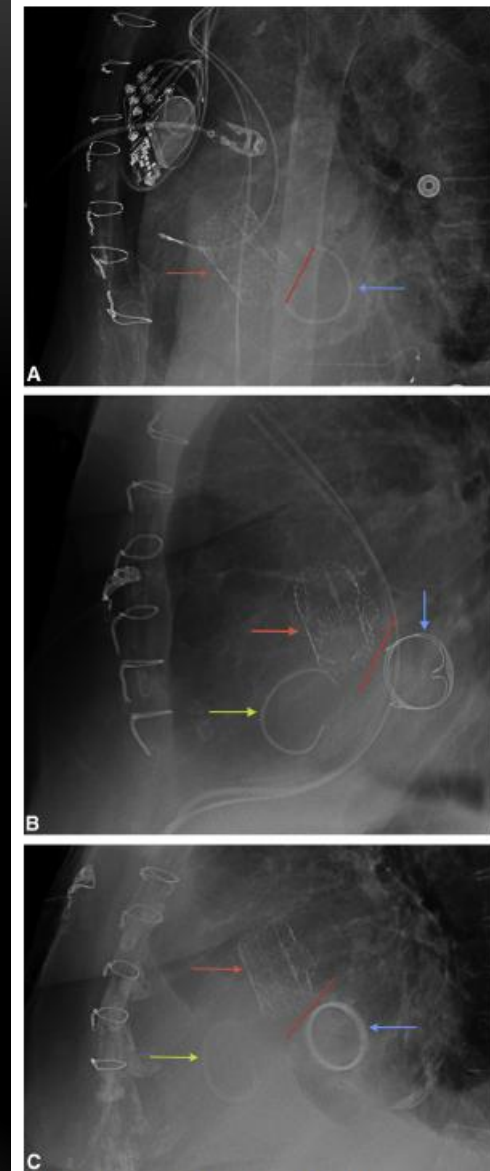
Postoperative lateral chest radiographs showing the absence of interference between the Perceval S and mitral prostheses. A, Sorin Annuloflex partial ring for mitral annuloplasty. B, Carpentier-Edwards Perimount Magna Mitral Ease bioprosthetic valve. C, Sorin Carbomedics mechanical mitral prosthesis. The *blue arrow* points to the mitral prosthesis. The *red arrow* points to the Perceval aortic sutureless bioprosthesis.
